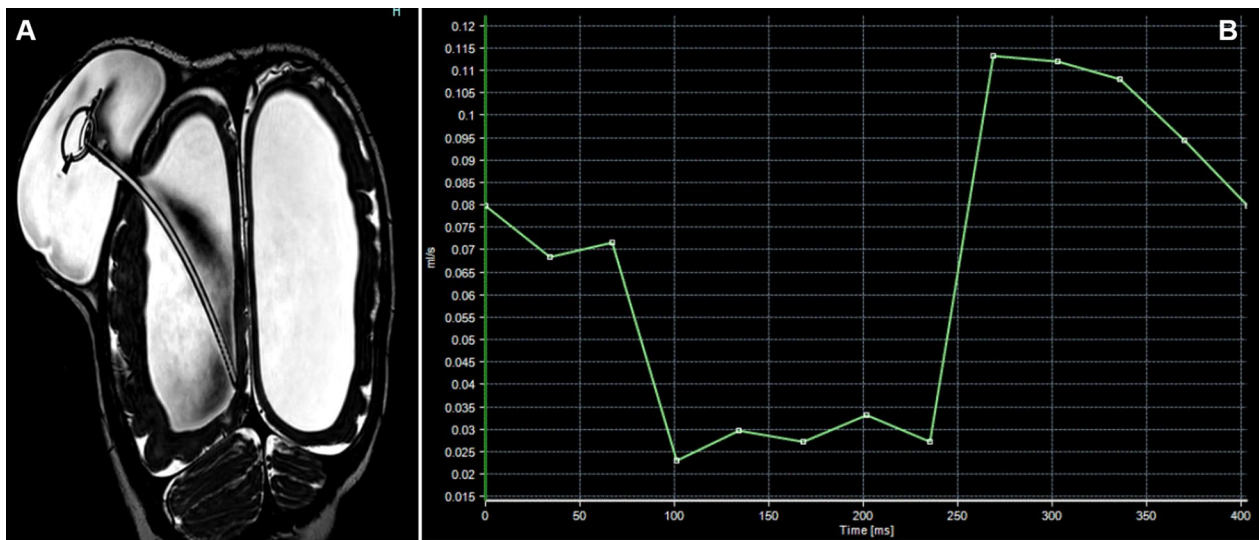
A 9-month-old girl presented with scalp swelling. A Reconstructed 3D-DRIVE in coronal oblique plane shows fluid collection surrounding shunt reservoir near skull burr hole; the proximal catheter and reservoir are seen patent with no evidence of disconnection. Turbulent CSF flow-related artifact is noted within the ventricular system and fluid collection as well (appreciated in FLAIR sequence, not shown). B CSF flow curve shows high flow rate values (flux: 0.1 ml/sec)
